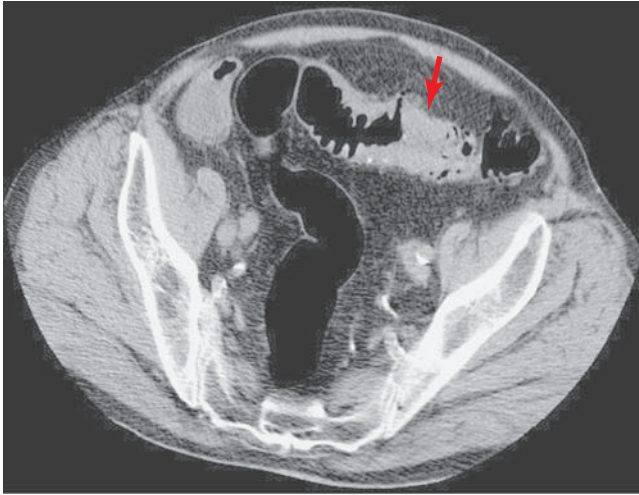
CT scan of active diverticulitis with occlusion of colonic lumen secondary to inflammation (*arrow*). Differential diagnosis is a sigmoid colon malignancy.
